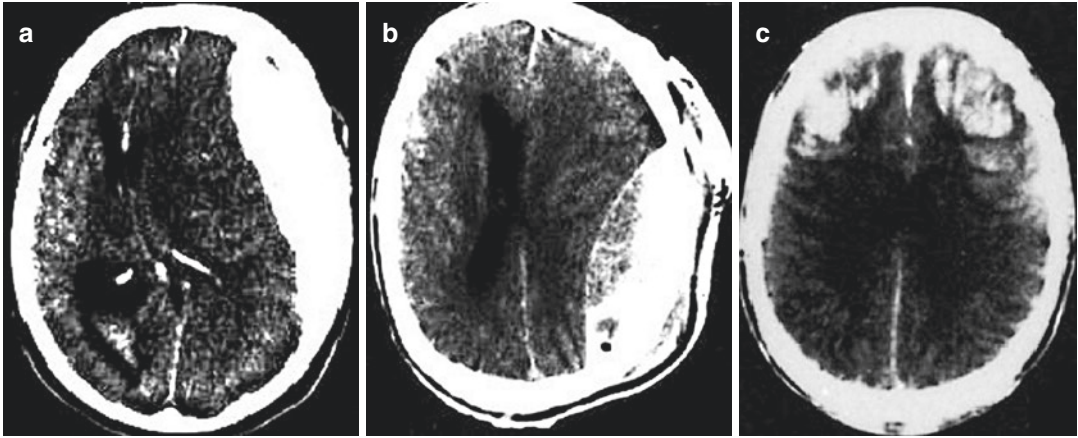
CT scan of the head showing different findings in severe traumatic brain injury. (a) Crescent shaped hyperdensity in the suggestive of left sided acute subdural hematoma with mass effect and left to right midline shift.
